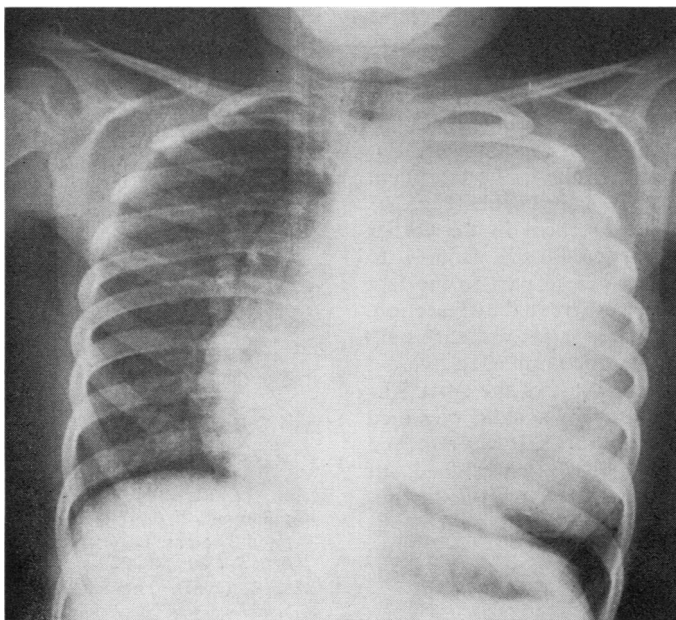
Case 2. Radiograph showing 16 cm pulmonary hydatid cyst in a child aged 5. The mass fills the left hemithorax, displacing the mediastinum and indenting the lower trachea and narrowing the left stem bronchus.
